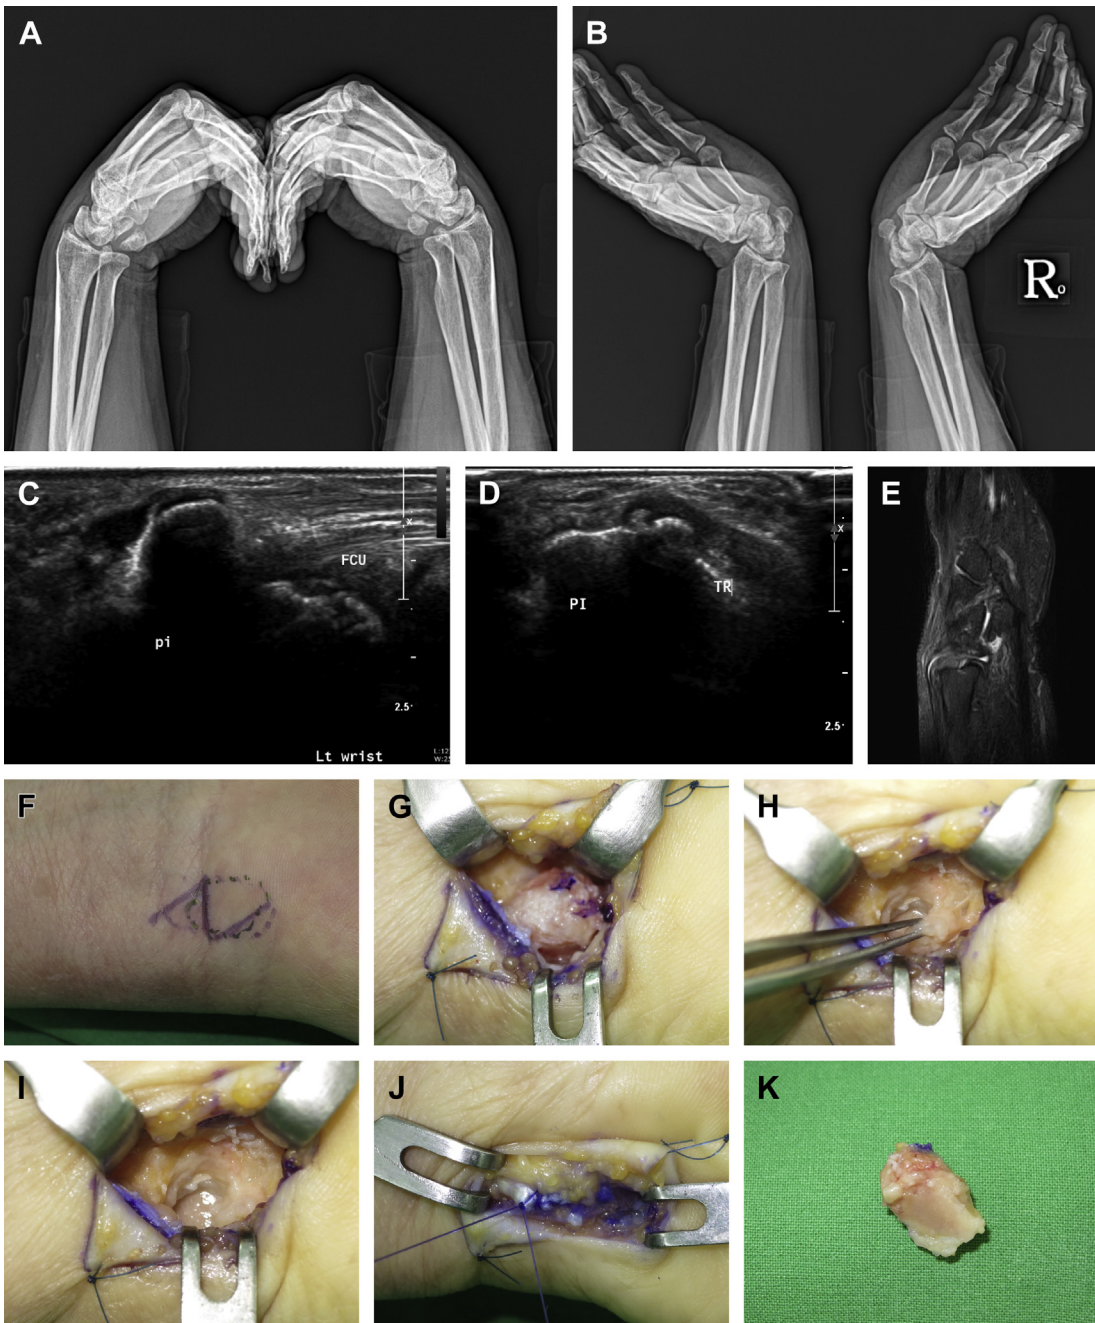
(A, B) A 55-year-old female patient with severe pain in the left wrist. On semisupination oblique view of the wrist (pisiform bone view), the pisotriquetral joint of the left wrist showed marked joint space widening and sclerotic change. (C, D). Axial and longitudinal images of ultrasonography show mild FCU tendon thickening and some fluid collection around the pisiform. (E) Fat-suppression T2-weighted sagittal image showed FCU thickening with increased signal intensity and osteophytes and cartilage loss of the pisotriquetral joint. (F, G) Through the Z-shaped incision on the volar crease of the ulnar wrist, pisiform was subperiosteally dissected through the midline splitting of the FCU tendon. (H) Incidental osteophyte in the pisotriquetral joint was removed. (I) Cartilage of the triquetrum was denuded. (J) After excision of the pisiform, the flexor carpi ulnaris tendon was repaired with 4-0 PDS suture in a continuous figure-of-eight method. (K) Excised pisiform showed almost totally denuded cartilage of the pisiform. TR, triquetrum; PI, pisiform.
